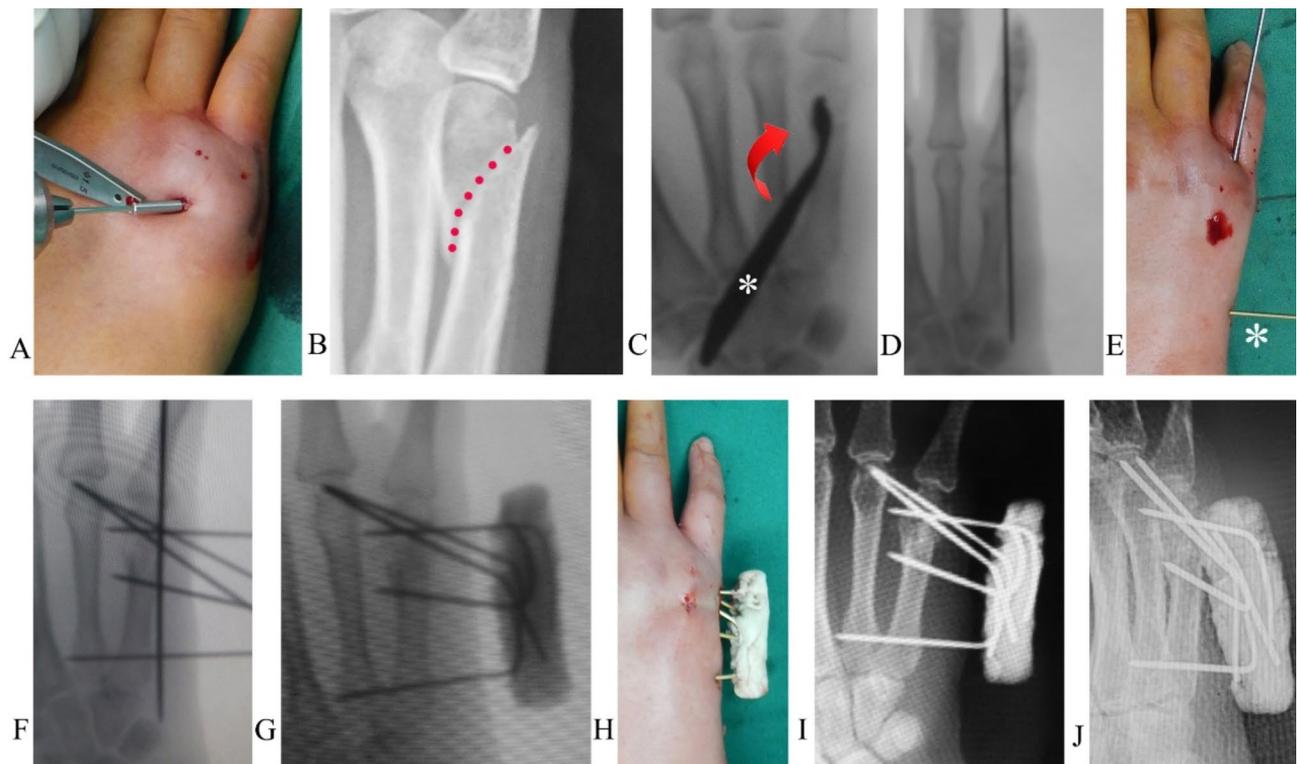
Osteotomy, fixation, and bone grafting. A. Osteotomy through a 3-mm incision made over the dorsoradial aspect of the metacarpal. B. Osteotomy line marked on a PA X-ray. C. The fifth metacarpal neck is fractured by inserting and rotating (arrow) a mini bone elevator (*), and the distal fragment is reduced with the elevator. D. Reduction is temporarily maintained using a K-wire inserted manually into the soft tissues surrounding the fifth metacarpal. E. A The proximal fragment is stabilized to the fourth metacarpal using a 1.5-mm transversal K-wire (*). F. A PA X-ray shows more K-wires are added. G. The wire ends are bent and mounted with bone cement. H. Appearance. I. A PA X-ray shows bone healing after 6 weeks. J. An oblique X-ray
